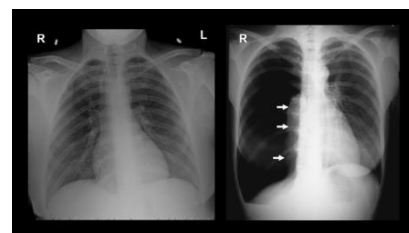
Atelectasis on an x-ray
